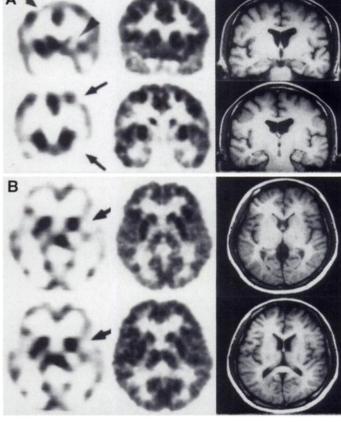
Coronal sections (A) and transaxial sections (B) of 30-yr-old female patient (Patient 8). Brain ^{99m}Tc-HMPAO SPECT (left) reveals hypoperfusion areas in bilateral parietal lobes (arrows, upper and lower), left temporal lobe (arrow, upper) and left basal ganglion (arrowhead, lower). However, brain FDG PET (middle) and MR images (right) reveal normal metabolism and signal intensity in these areas found in ^{99m}Tc-HMPAO SPECT
